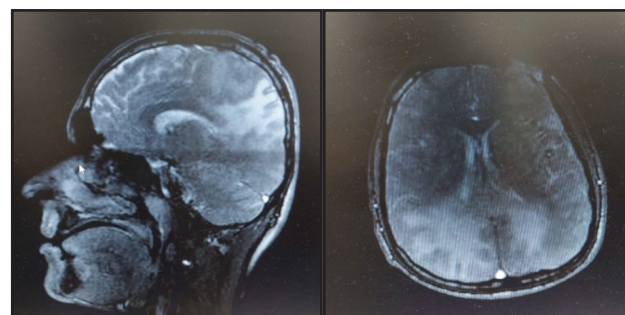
Cranio-cerebral MRI with contrast, sagittal, and transverse planes are shown.
